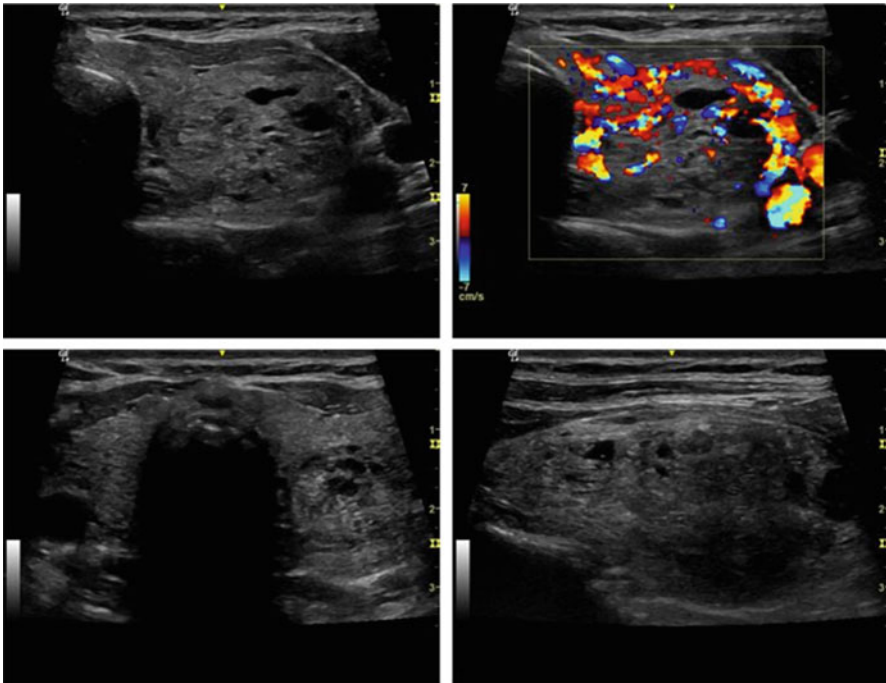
Thyroid gland of a patient with a goiter. Top left: left lobe transverse, same lobe with color Doppler (top right), bottom left entire gland transverse, bottom right longitudinal
